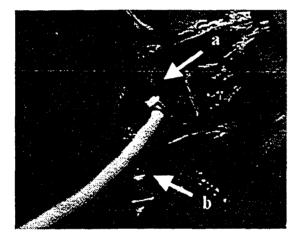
Fig A-2: Ultrasonic flow probes on (a) the hepatic artery and (b) the portal vein
